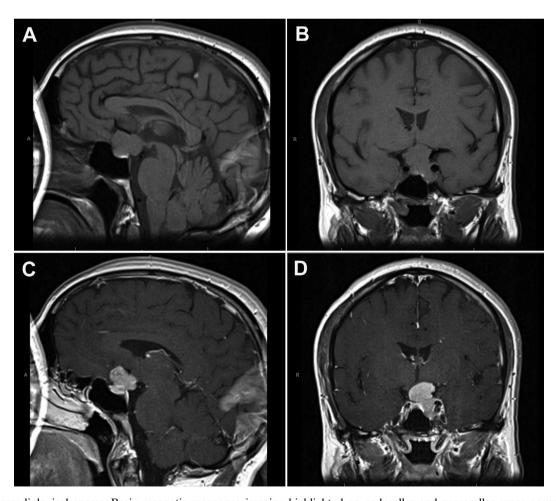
Neuroradiological exams. Brain magnetic resonance imaging highlighted an endosellar and suprasellar space-occupying lesion, with greatest axis of 28 mm, isointense in T1 sequences with a homogenous contrast enhancement. (A, B: sagittal and coronal T1-w before contrast enhancement; C, D: sagittal and coronal T1-w after contrast enhancement).
